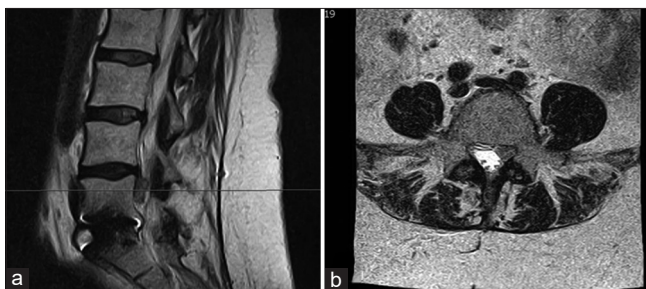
Preoperative T2-weighted magnetic resonance imaging in (a) sagittal and (b) axial views demonstrating the left-sided lateral recess epidural venous plexus at the adjacent level above a fusion mimicking a herniated disk associated with adjacent segment disease.
